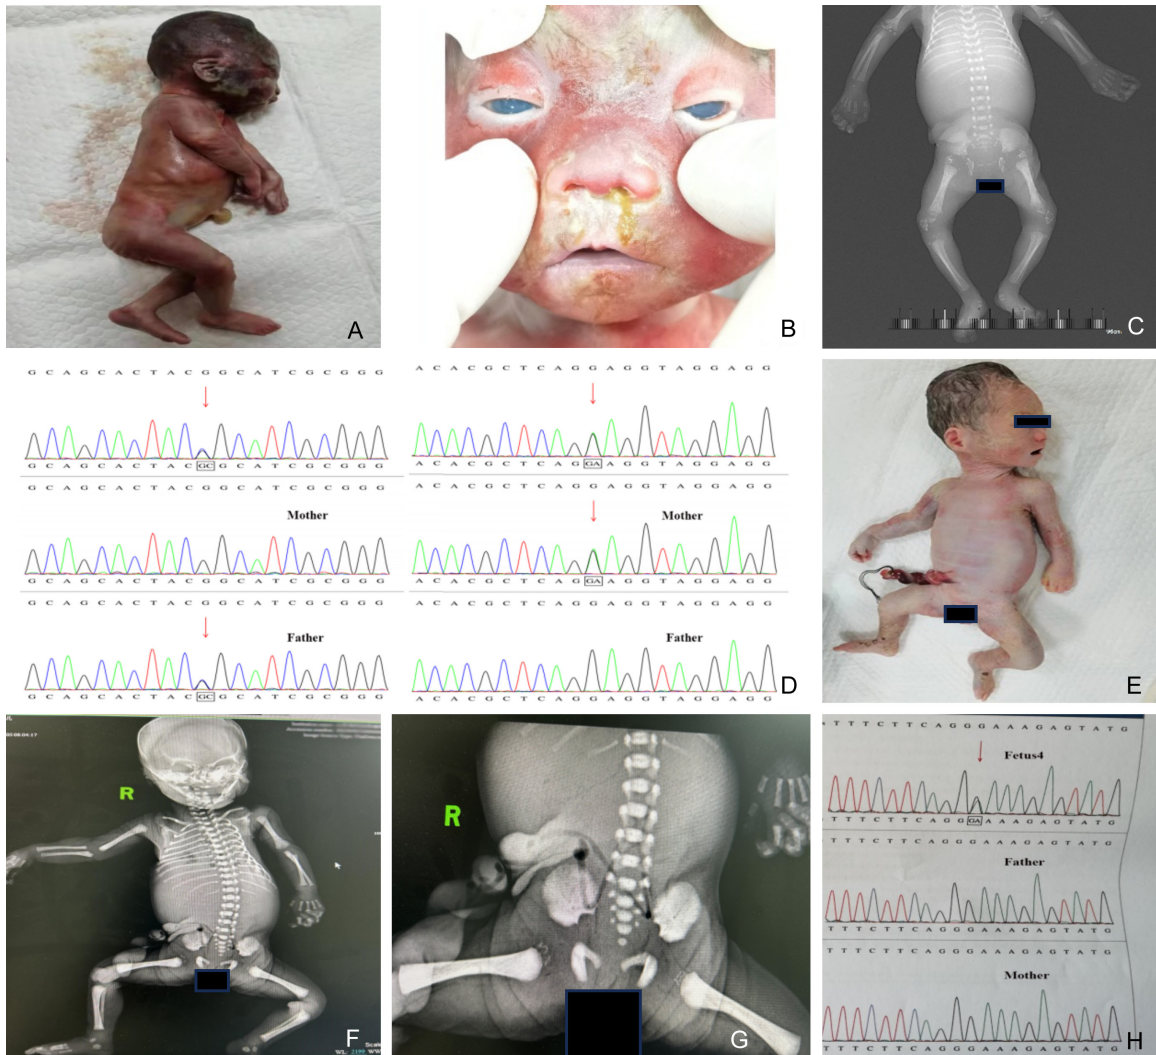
Clinical findings, radiological features and WES in two fetuses. A-D. Fetus 1(25+5wg*). E-H. Fetus 4(31+3wg*). A. Shortened upper arms and thighs; B. Flat nasal bridge and cataracts in both eyes; C. Multiple punctate ossification at the epiphyseal end of long bones and incomplete ossification of thoracic vertebrae by X-rays; D. PEX7 gene c.121G>C (p.G41R) and c.337G>A (p.E113K) exhibiting compound heterozygous variation, inherited from its father and mother; E. Shortened long bones of the limbs and flat nasal bridge; F, G. Shortened long bones and thick metaphysis of the femur with epiphyseal stippling by X-rays; H. EBP gene c.303G>A (p.W101) exhibiting a new mutation, not inherited from its parents. Abbreviations: WES, whole exome sequencing; wg*, weeks of gestation.
